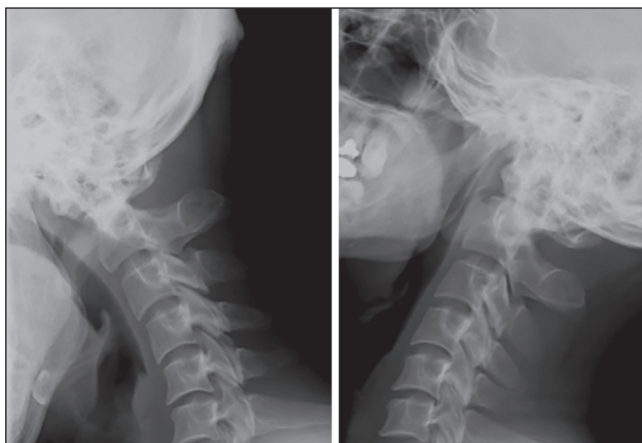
Lateral radiographs of cervical spine showing an os odontoideum and atlantoaxial instability during flexion-extension
